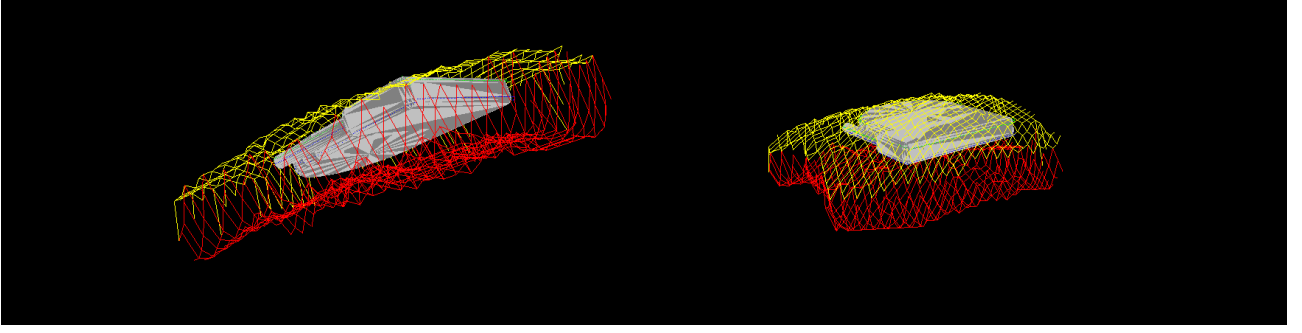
Implant volume (Combi40+), with position optimized within a reconstructed 3D ultrasound skull volume (left: seen from below, with no implant parts protruding below the lower skull surface; right: seen from above, with the implant top approximating the outer skull surface).
